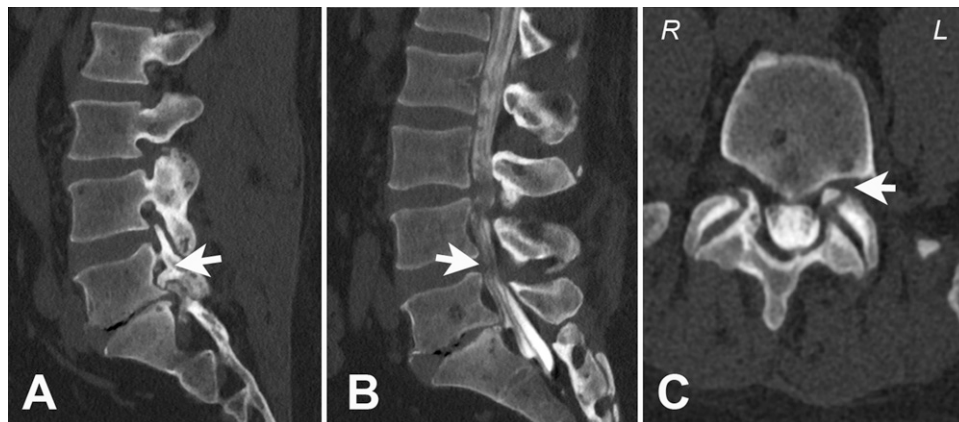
A: Sagittal lumbar CT myelogram revealing severe left foraminal stenosis (arrow) compressing the L5 nerve root. B: Midsagittal view showing severe central spinal stenosis (arrow) at L4–5. C: Axial view revealed severe left foraminal stenosis (arrow).
